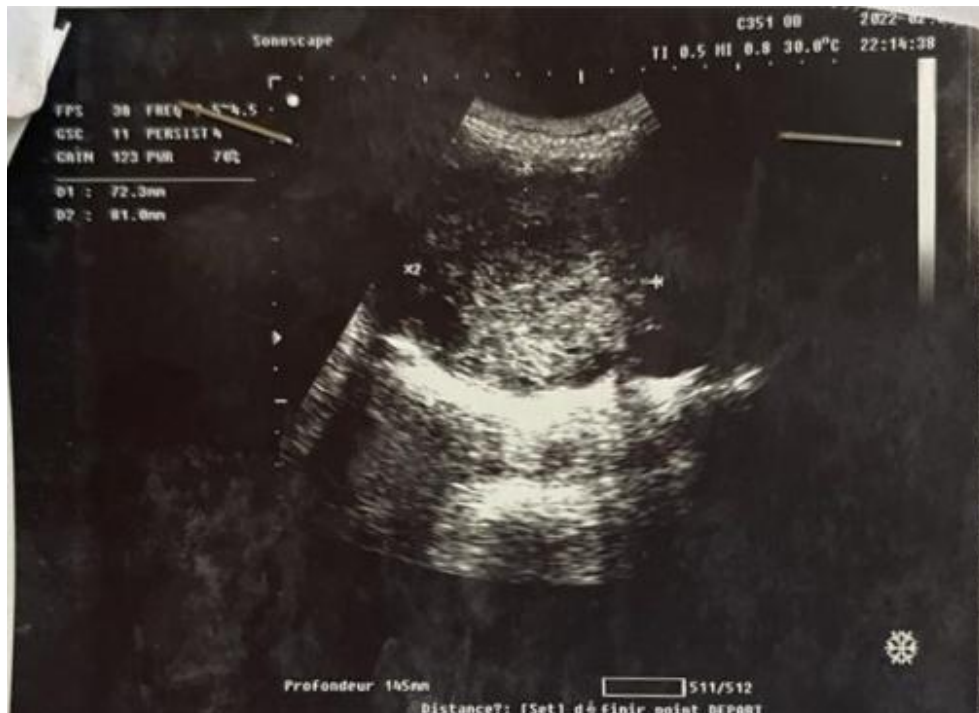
Ultrasound image of the praevia mass
